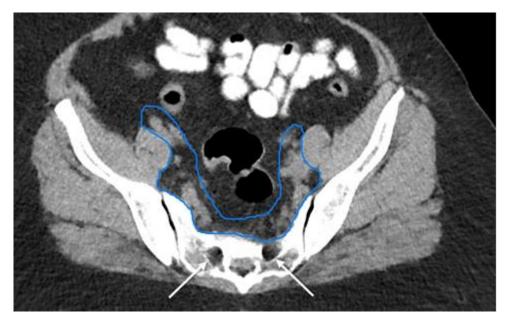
Contouring steps for internal and external nodal region on a CT scan, A contour of illiac vessels, B :extension of vessel volume, C : CTV-E (blue)
